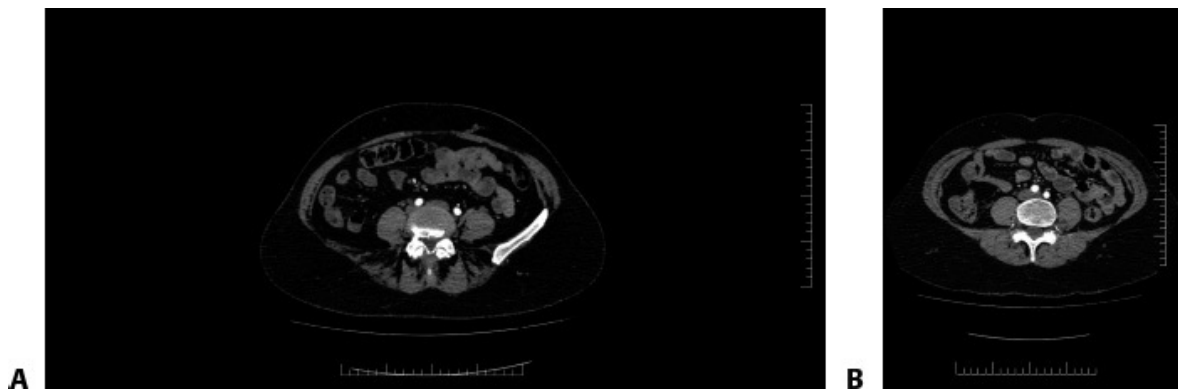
• A. CTA of a patient's abdomen demonstrating an obvious dominant perforator (greater than 1.5 mm in size) coming from the medial branch of the left DIEA. This patient will likely be a good candidate for a DIEP flap. B. The largest perforator seen on the right hemiabdomen is shown here and is quite small in size (less than 1.5 mm). Intraoperatively, it may be determined not to be reliable enough to support the flap. More perforators may be required, and in this case, a free TRAM or MS-TRAM would be considered.
